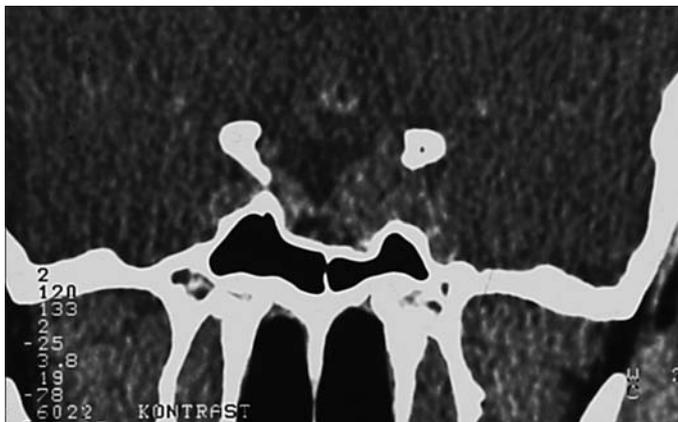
Postoperative CT scan. After transsphenoidal resection of the tumor, there is no mass, but bone destruction remains
